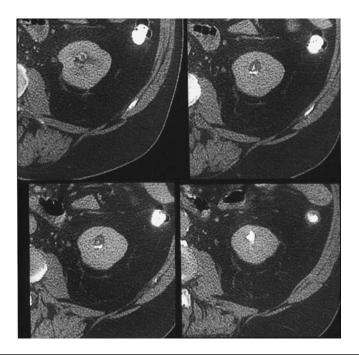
Noncontrast CT scan of a left renal calculus. Note its hyperdense (bright) appearance, which is similar to bone.
